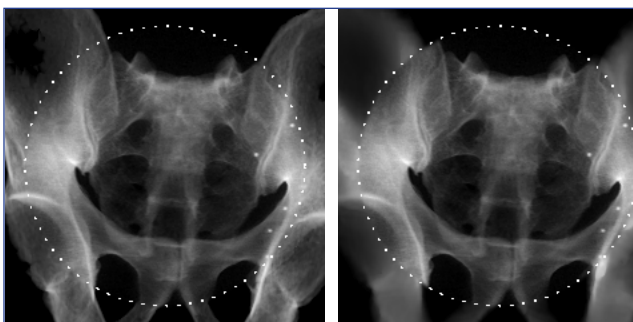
Fusion of pelvis x-rays (in circle), registered to prior CT (left) and statistical atlas (right) outside the circle. The projections outside the circle compensate for image truncation.
